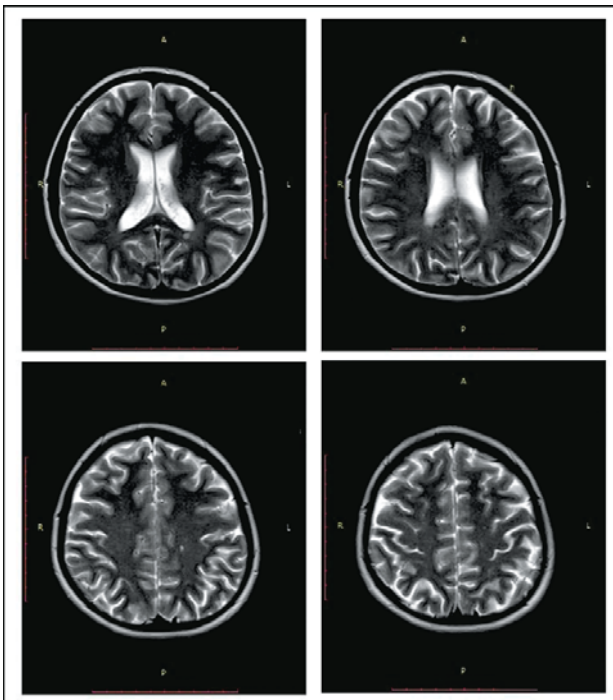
Brain MRI scans showed multiple demyelinating lesions in acute phase
